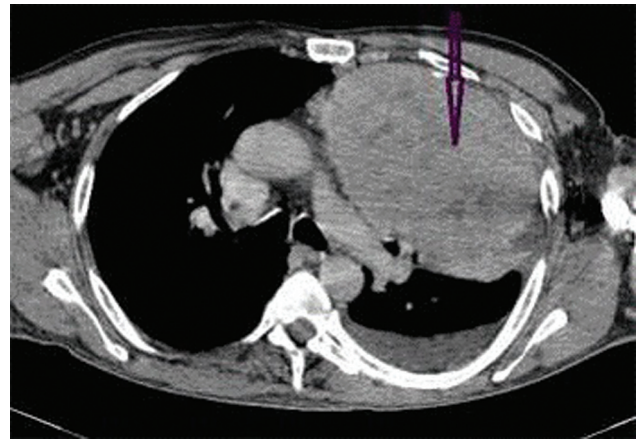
Axial contrast-enhanced computed tomography image demonstrating a well-defined lobulated anterior mediastinal mass (arrow) with mixed attenuation suggesting a diagnosis of thymoma.
